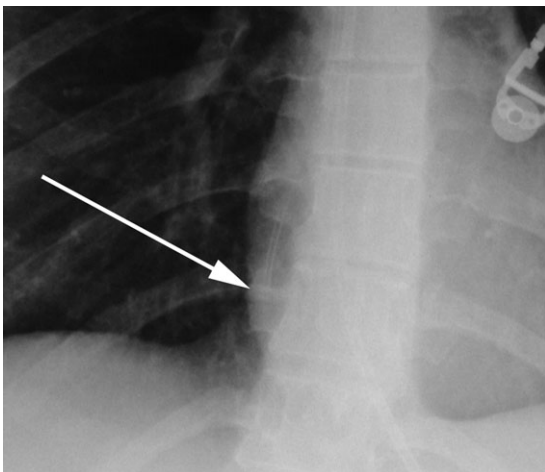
Immediate postoperative chest radiograph. The tip of the catheter is seen to lie within the right atrium (arrow).
